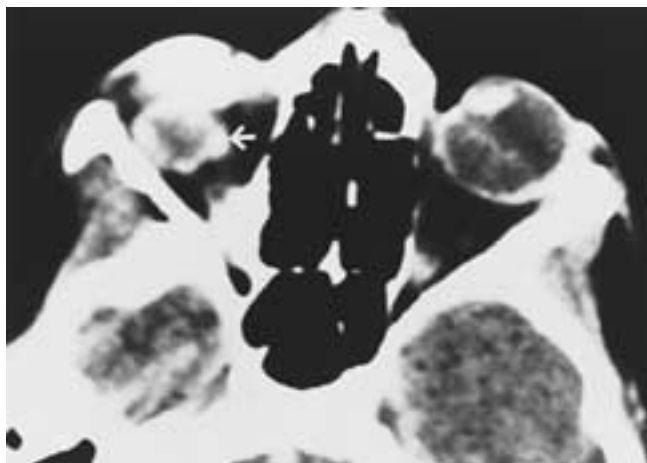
Recurrent retinoblastoma. Axial CT scan shows recurrent disease (*arrow*) after enucleation. Note the right false eye. (Courtesy of Dr. G. Schullman.)
